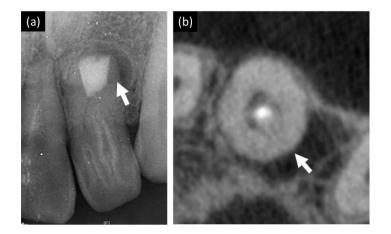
Detection of missing lateral canal of #22 (a) Periapical view (b) Axial view of cone-beam CT
